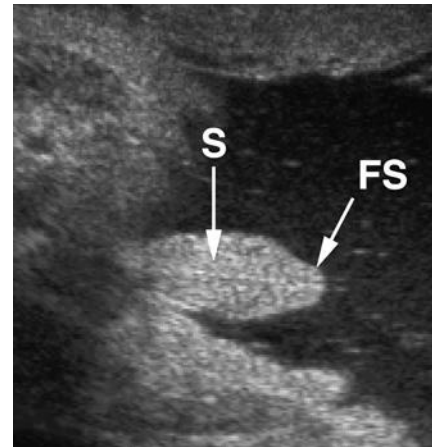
Nonerect fetal penis seen sonographically. FS, foreskin; S, shaft.
